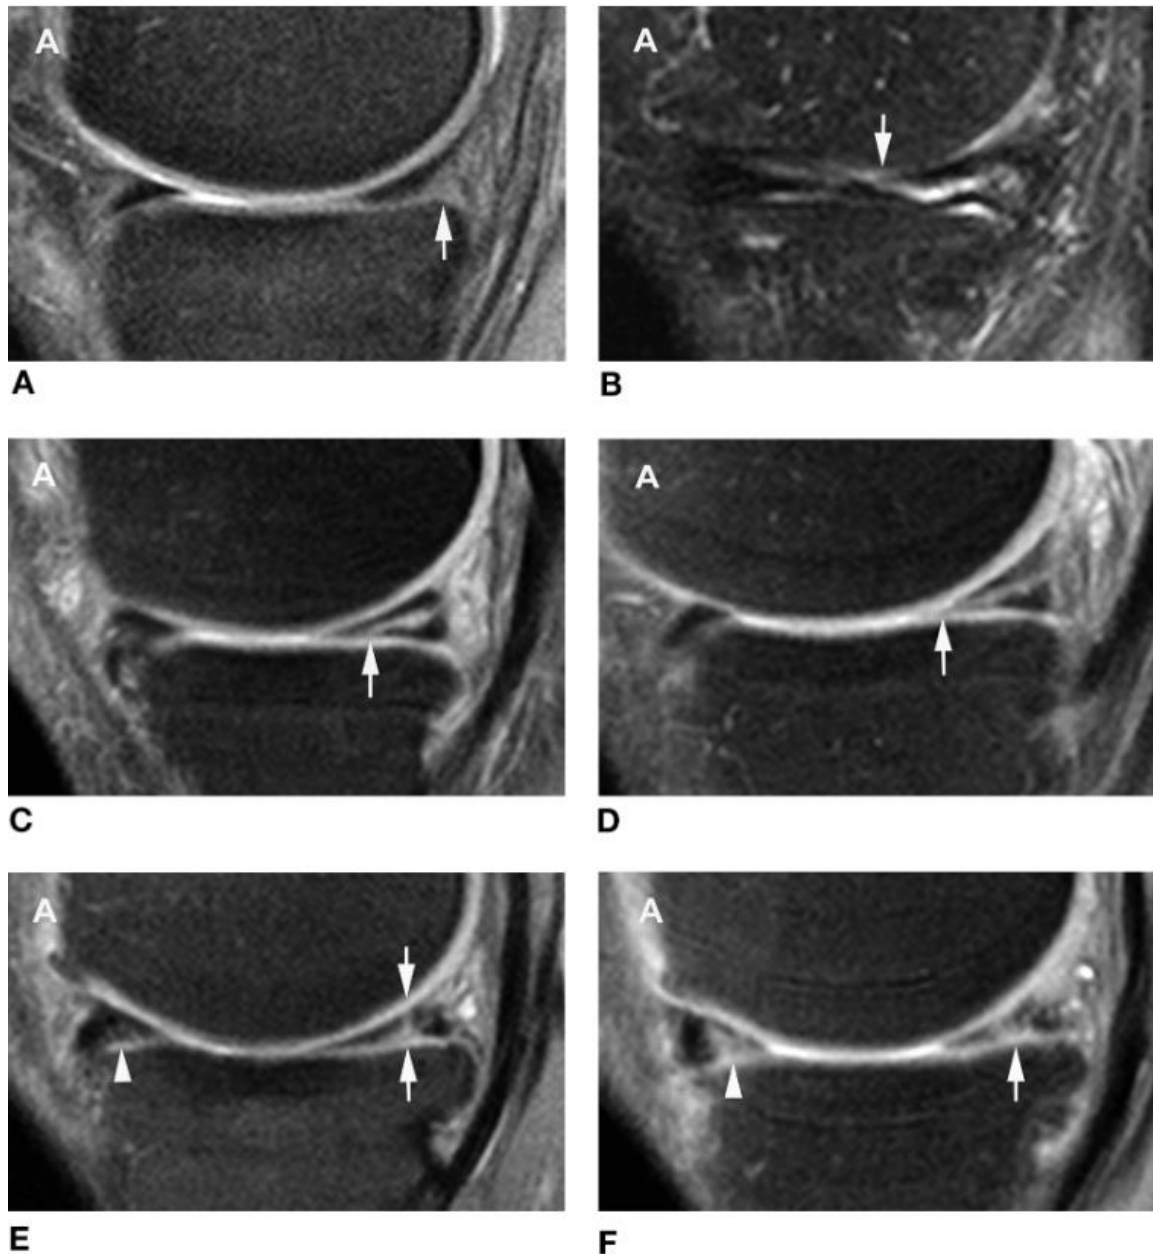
Sagittal MRI of the anterior and posterior one-third of the with type 1 to 6 signal intensities contacting one or both articular surfaces. (A) Type 1, broad intermediate SI in peripheral 1/5 of posterior third in contact with tibial surface (*arrow*). (b), (c) & (d) Type 2a & 2b intermediate SI contacting tibial surface with some not the extending to the posterior articular surface (*arrow*). (e) Type 2c, intrameniscal intermediate SI contacting both femoral and tibial surfaces (*arrows*); one definite and 2 possible SI in contact with tibial surface of anterior third (*arrowhead*). (f) Type 3, comminuted lesions in contact with both surfaces of anterior (*arrowhead*) and posterior third (*arrow*).
